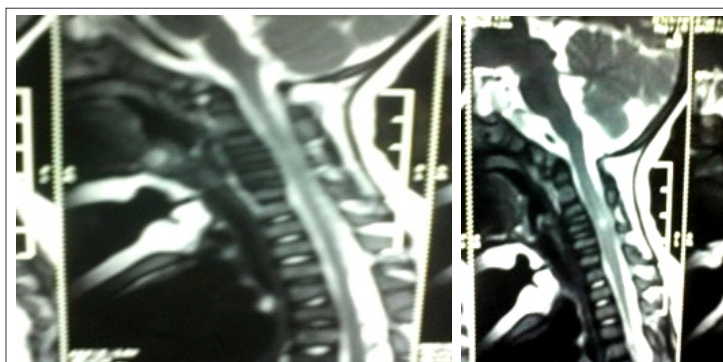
MRI Images showing non hemorrhagic cord edema at C4 level, with suspicious tear of anterior longitudinal ligament at that level
